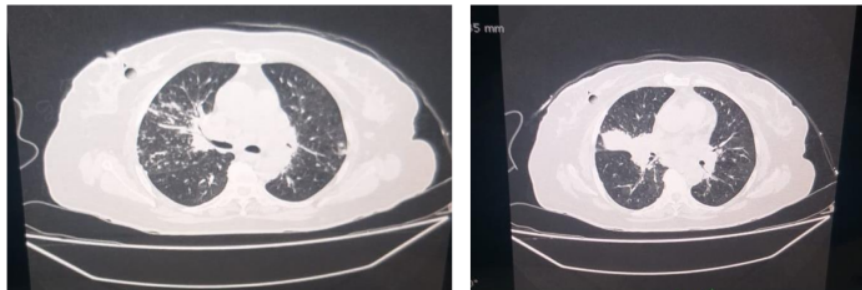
Chest CT Scan Findings Pre- Treatment
